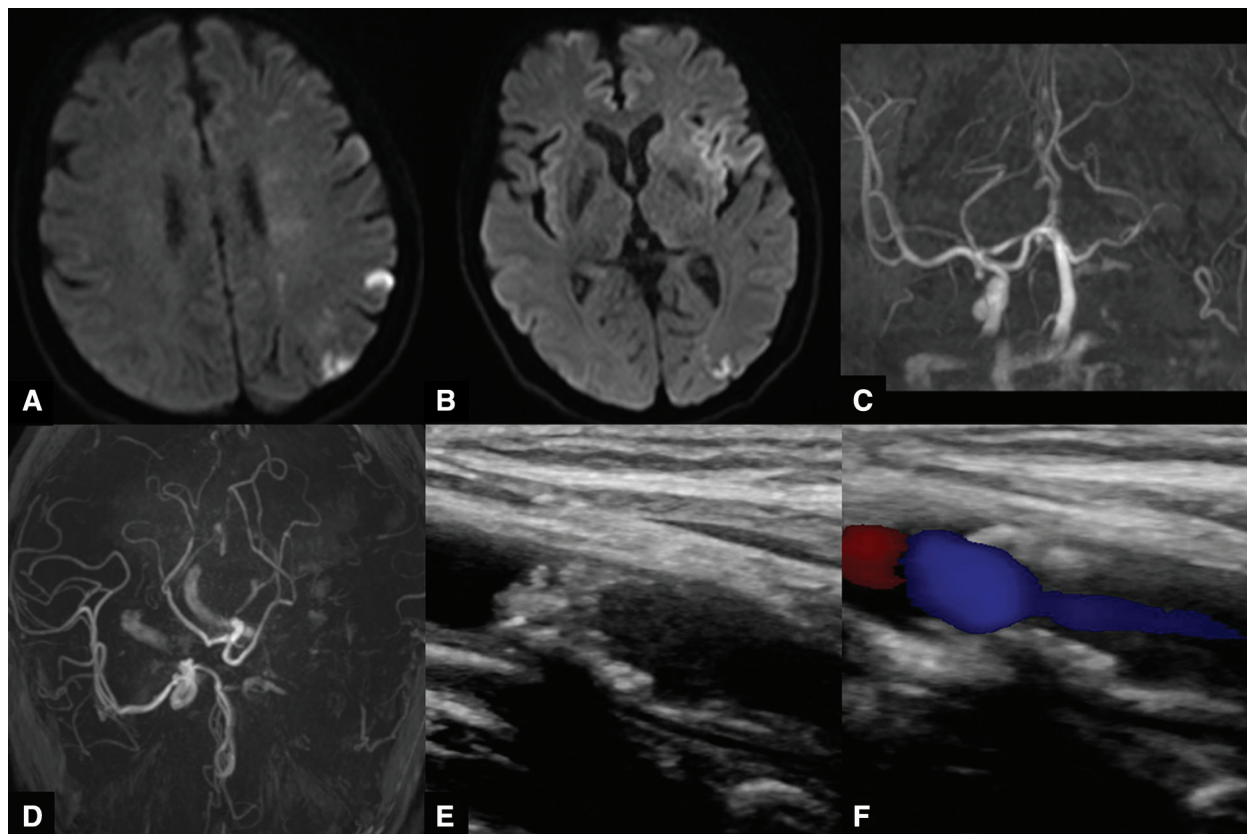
MRI on admission. (A and B) DWI showed small acute infarctions in the left MCA territory. (C and D) The left ICA was not visualized on MRA, and the distal M1 segment of the left MCA was obstructed. (E and F) Carotid ultrasonography image of the left ICA showed stenosis with high echoic plaques. The peak systolic velocity was 2.3 m/sec. There was no evidence of dissection in the cervical carotid artery. DWI: diffusion-weighted image; ICA: internal carotid artery; MCA: middle cerebral artery
